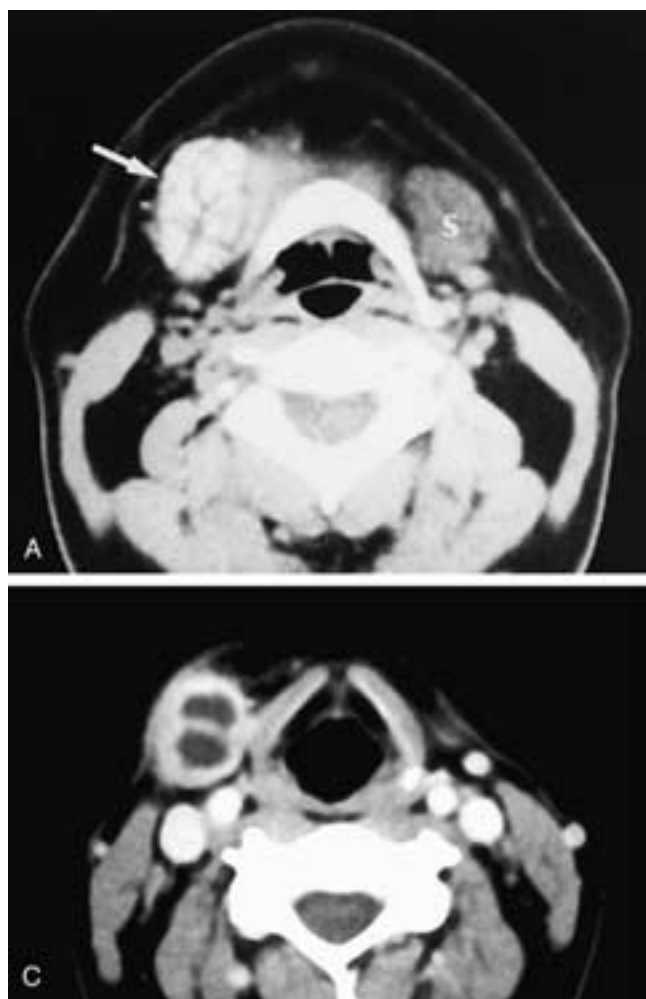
Axial contrast-enhanced CT scans on three different patients. In A, there is an enhancing mass (*arrow*) in the right submandibular gland. *S*, the normal left submandibular gland. In B, there is a partially cystic mass in the right submandibular gland. There is a nonuniform rim, which is thicker laterally. The lesion has sharply defined margins. In C, there is a partially cystic, well-defined mass with a central septation within the right submandibular gland. All of these patients had pleomorphic adenomas.
